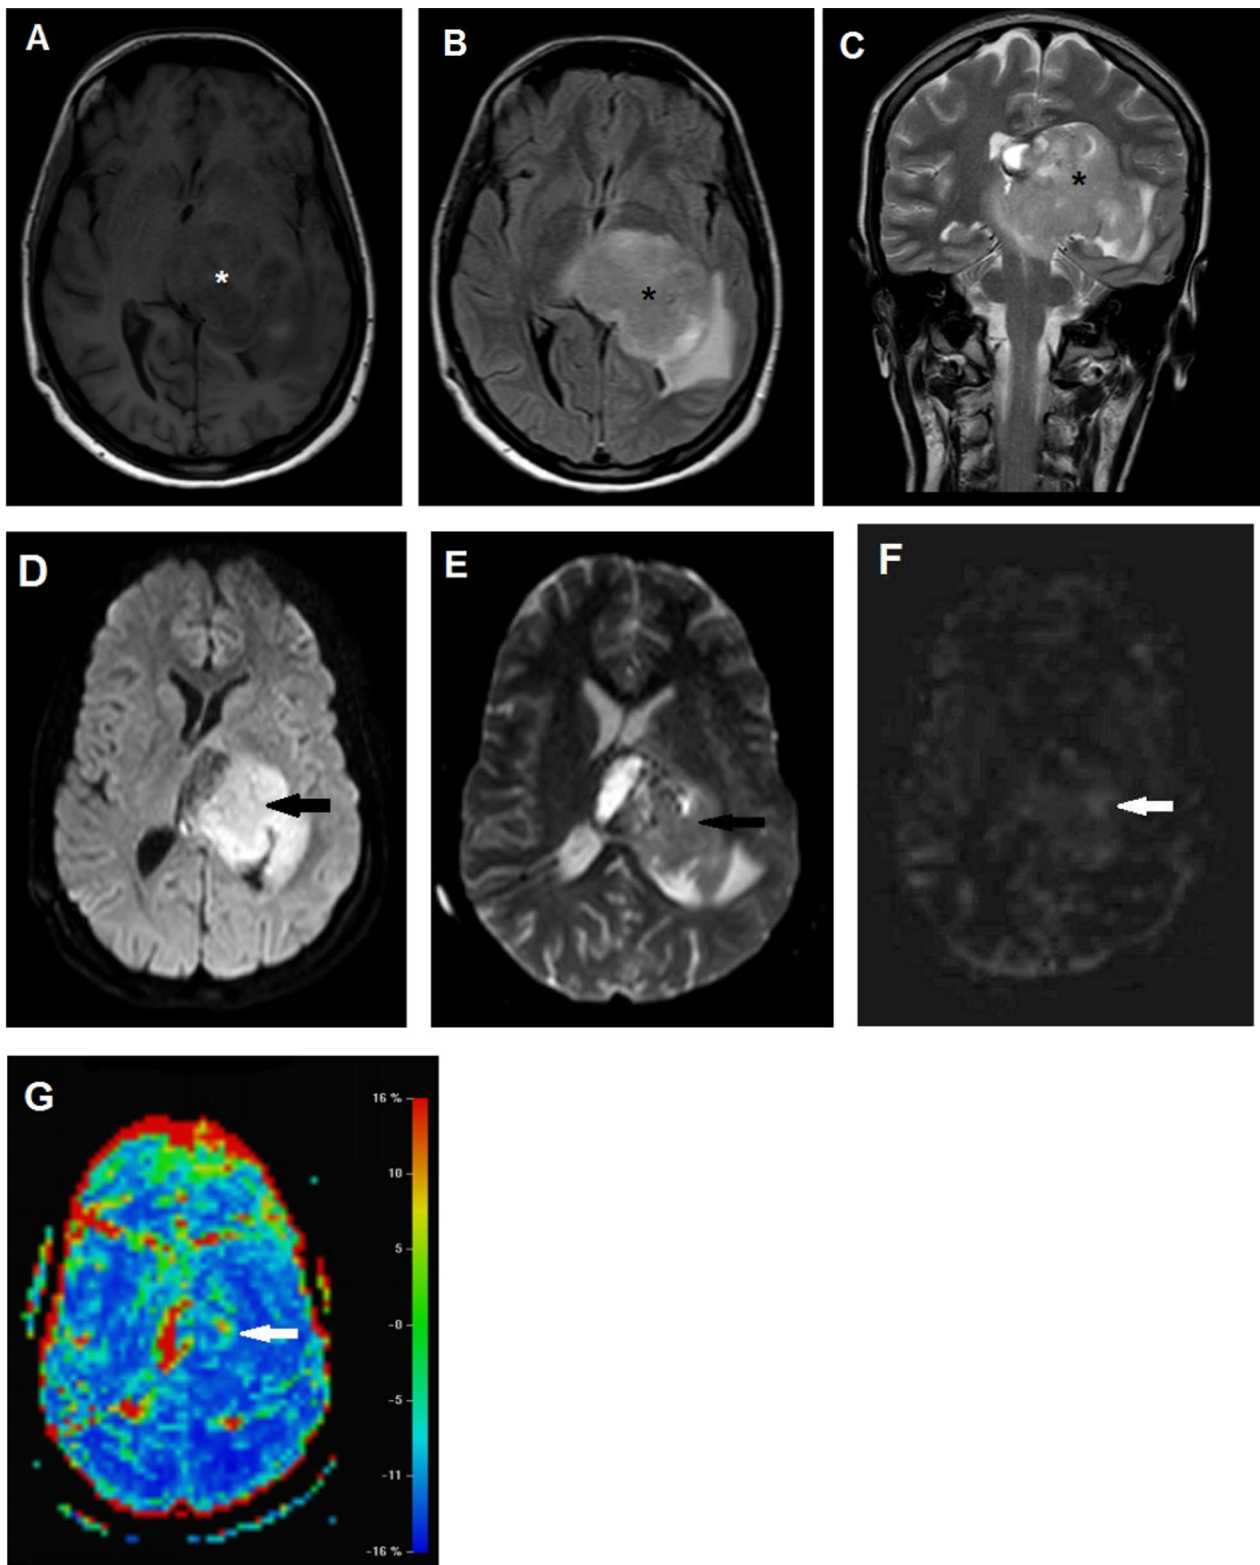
A 16-year-old girl patient with a WHO grade IV glioma; images show a large mass of non-homogeneous signal intensity in the left thalamic and deep periventricular white matter (asterisk). It displays low SI on axial T1WI (A), high SI on axial FLAIR image (B). It is seen crossing midline with associated high T2SI edema and mass effect in coronal T2-weighted image (C). It shows restricted diffusion (black arrows) in the form of high SI on DWI (b1000 image) and low SI on ADC grayscale map (E, D). High perfusion of the mass (white arrows) is seen in axial ASL grayscale and color CBF maps (F, G)
